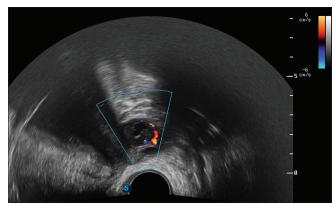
Transvaginal ultrasonography of a right adnexal mass with scanty Doppler flow around without fetus heartbeats 3 days after treatment
